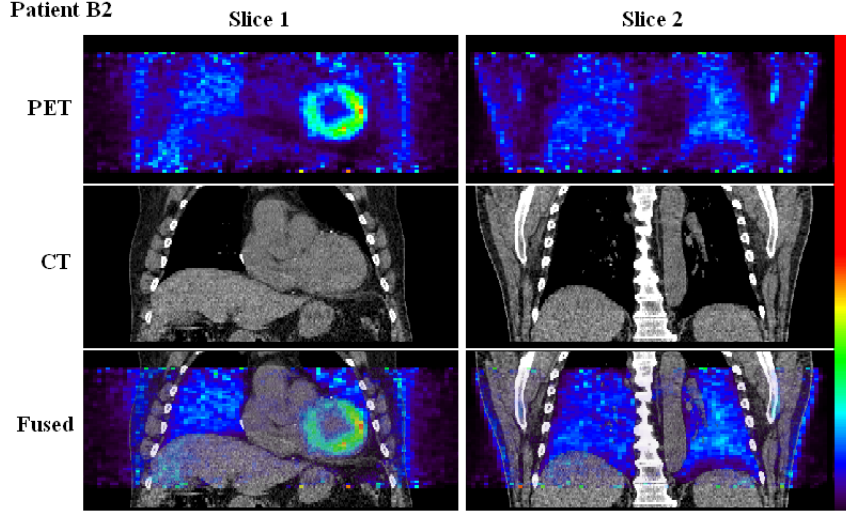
Coronal slices through a single frame of patient B2's PET-CT dataset, showing the PET, CT and fused PET-CT images for a slice traversing the heart (Slice 1) and a more posterior slice (Slice 2).
